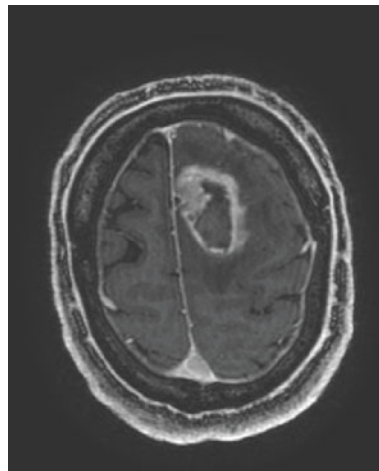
MRI scans of 4 patients with glioma (grade 4, WHO classification) with (i) survival time in days after surgery and (ii) the number of mutant epitopes recognized by the patients' TIL defined by IFN-gamma production in relation to the total number of mutations recognized. A focused TIL response appears to be associated with increased survival, an observation that needs to be followed up in larger studies
